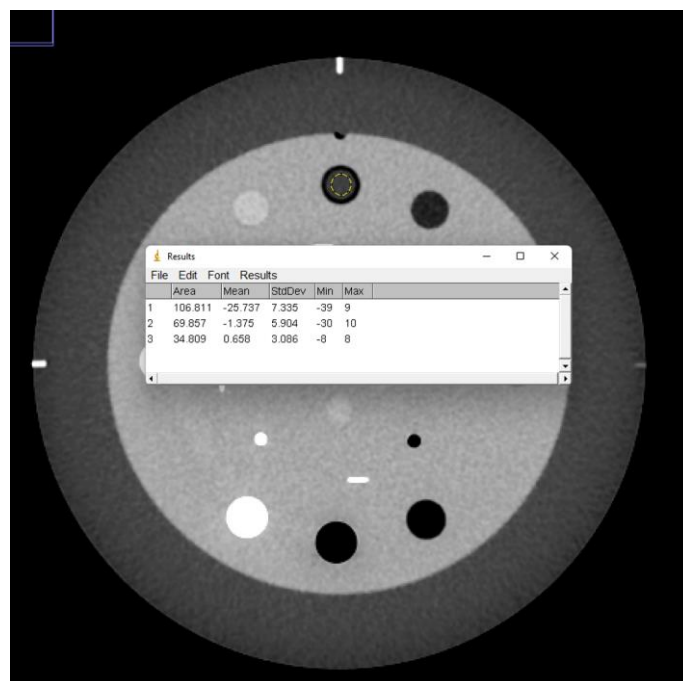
Locations of ROIs in material inserts with different densities for 'HU value' test in CT
